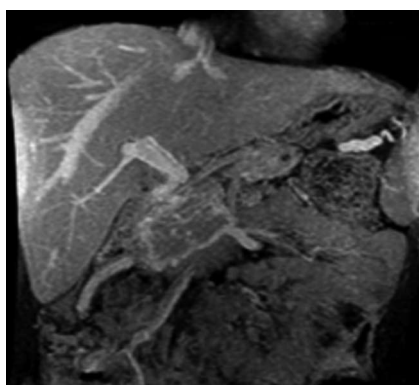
Magnetic resonance imaging film showing portosplenic thrombosis, gastric varices and pancreatoduodenal collaterals.
